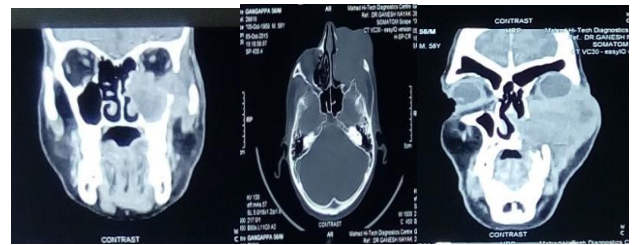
CT scan head and face
